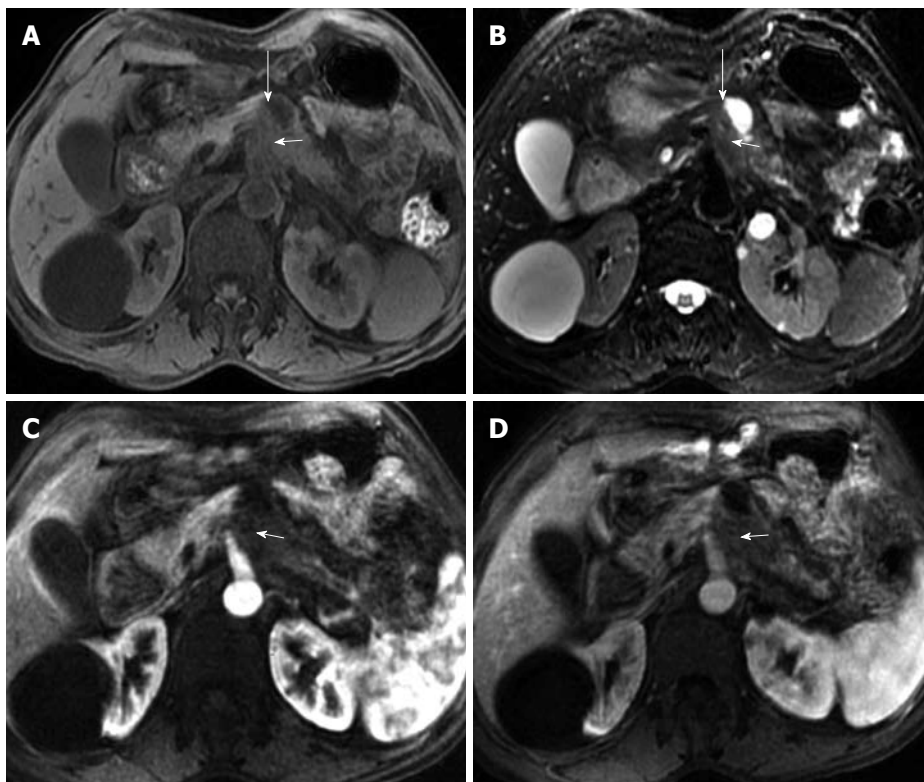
Example of patterns of extrapancreatic neural invasion by pancreatic carcinoma and the characteristics as visualized by magnetic resonance imaging. Fifty-seven-year-old female with pancreatic body carcinoma: magnetic resonance images. The tumor (short arrows) was located at the body of the pancreas which showed hypointensity on T1-weighted imaging (A), arterial phase (C) and venous phase (D), while it showed hyperintensity on T2-weighted imaging (B); there was streak-like signal intensity structure (long arrows) between pancreatic body and abdominal aorta.
